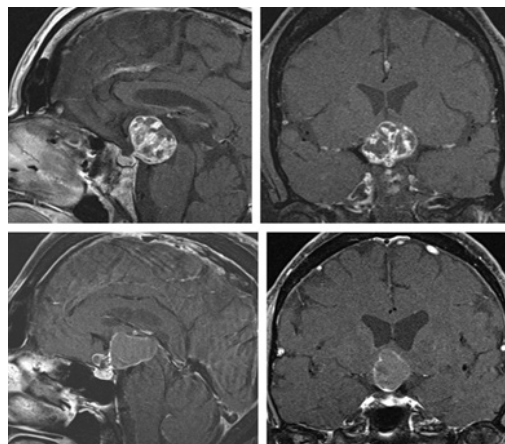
(MRI images from the web for demonstration): Above is mostly solid CP, and the bottom is partially cystic CP. Courtesy of Aaron Cohn-gadol.com and neurosurgicalatlas.com.
